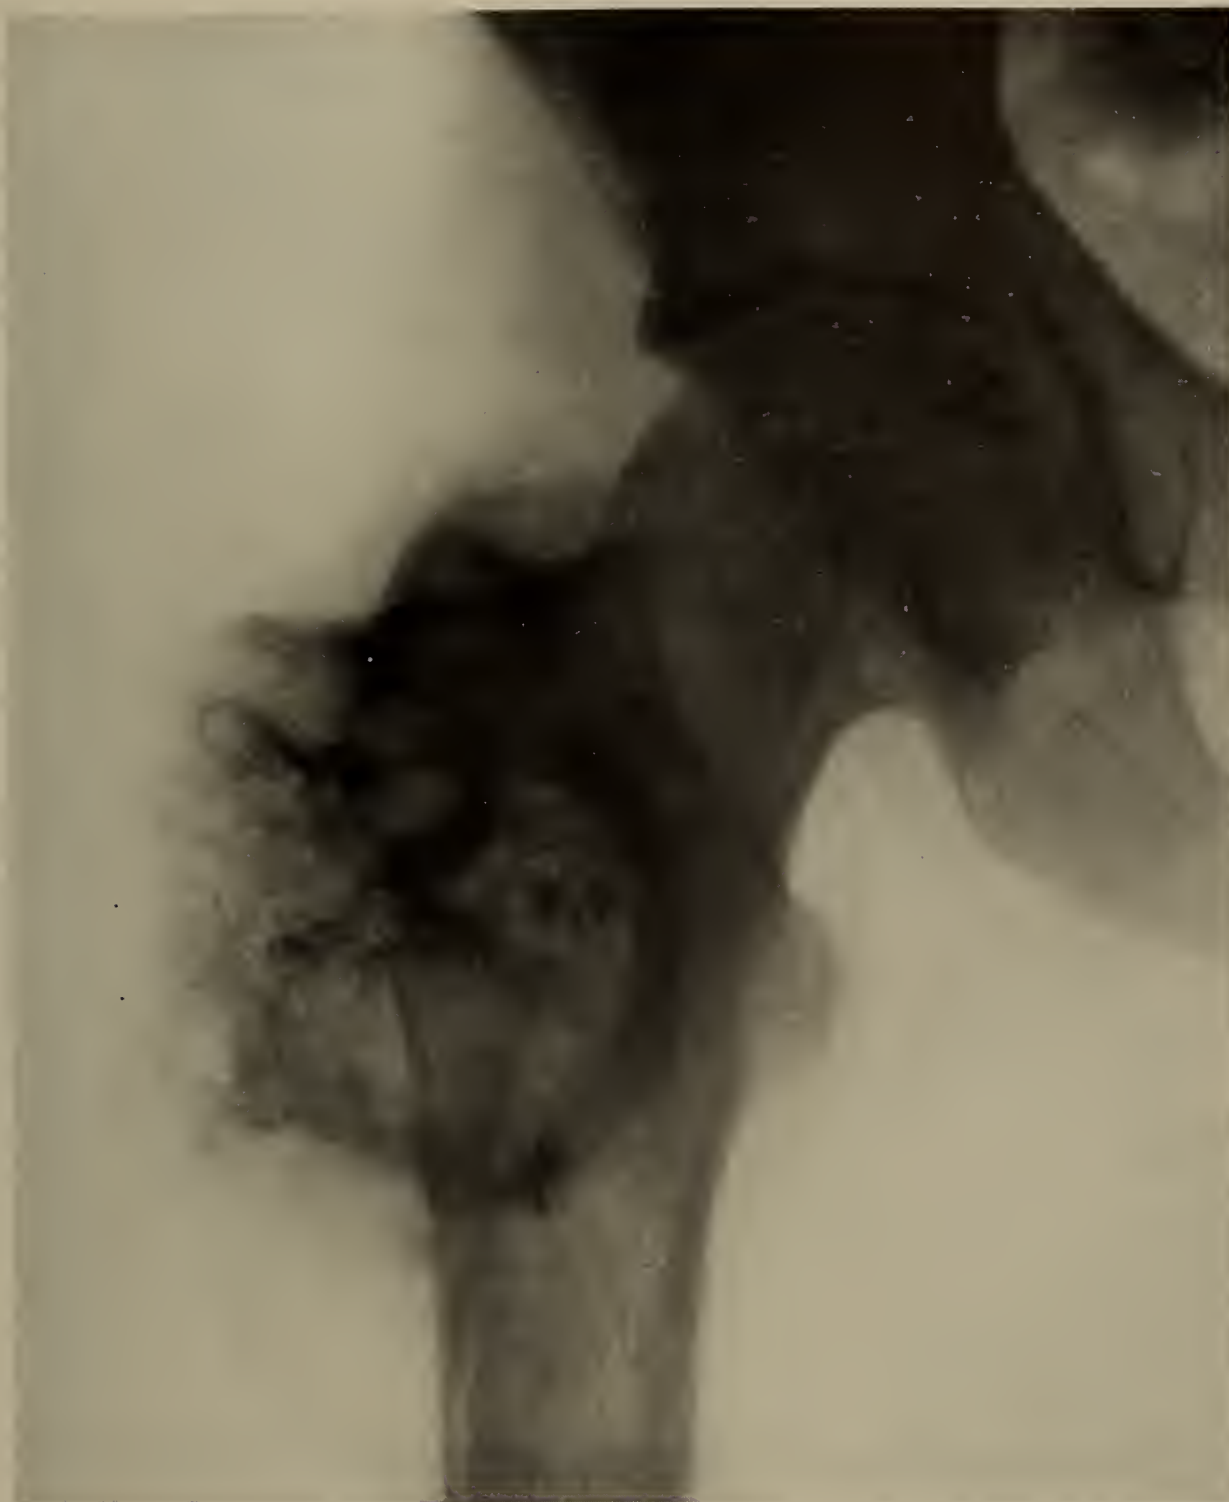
Case 535. Osteogenic sarcoma in a man 28 years old. The speckling in the roentgenogram is typical of osteogenic sarcoma of the upper femur, in the trochanteric region, due to excess of cartilage and calcification foci in it. Death 11 months after onset.
